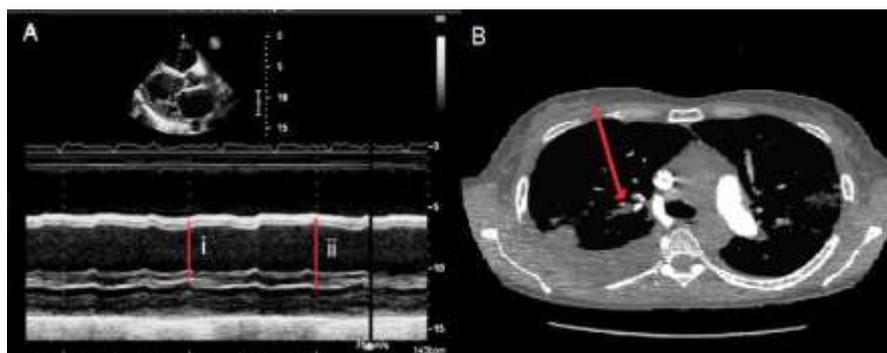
A) M-mode echocardiographic parasternal long axis view indicating minimal change in dilated LV dimension in systole (i) and diastole (ii), equating to an EF of 15%; B) CT pulmonary angiogram revealing multiple pulmonary arterial emboli, with the arrow demonstrating a prominent right lower lobar arterial embolus.
